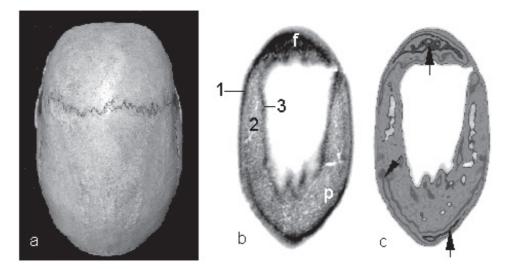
Image of the investigated cranial vault (a) and axial CT scan (b – original, c – modified); f – frontal bone, p – parietal bone; 1 – outer table of compact bone, 2 – middle layer of spongy bone (diploe), 3 – inner table of compact bone. The arrows indicate areas of the higher density.
